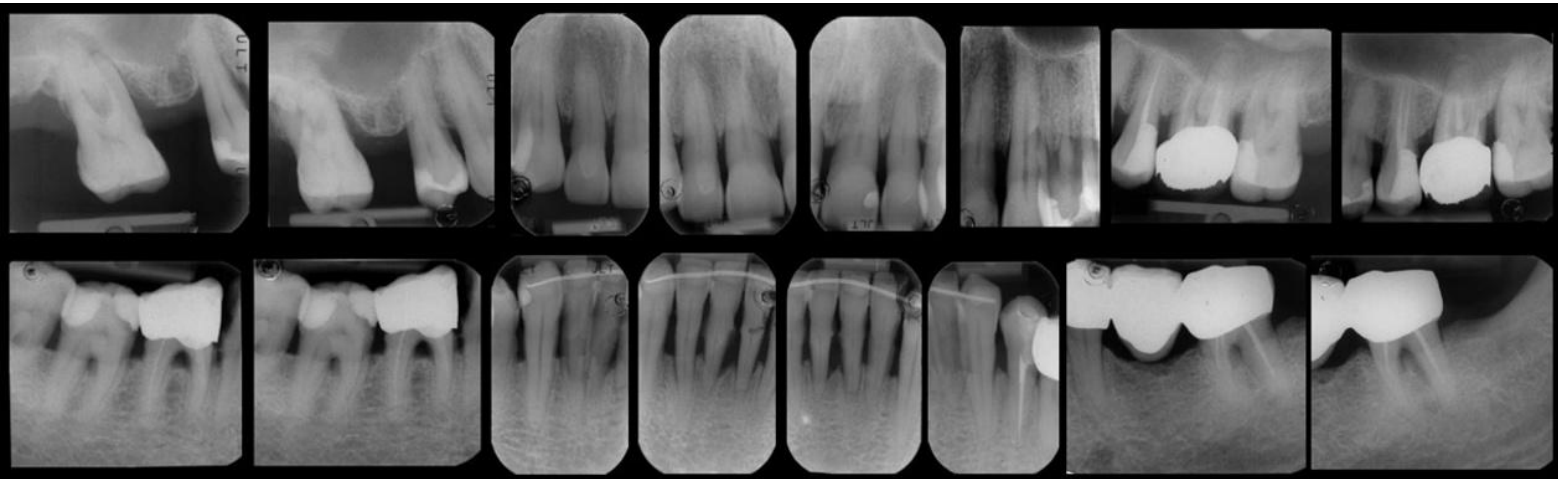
Same patient as in Fig. 20-1. Radiographs from the initial examination.
